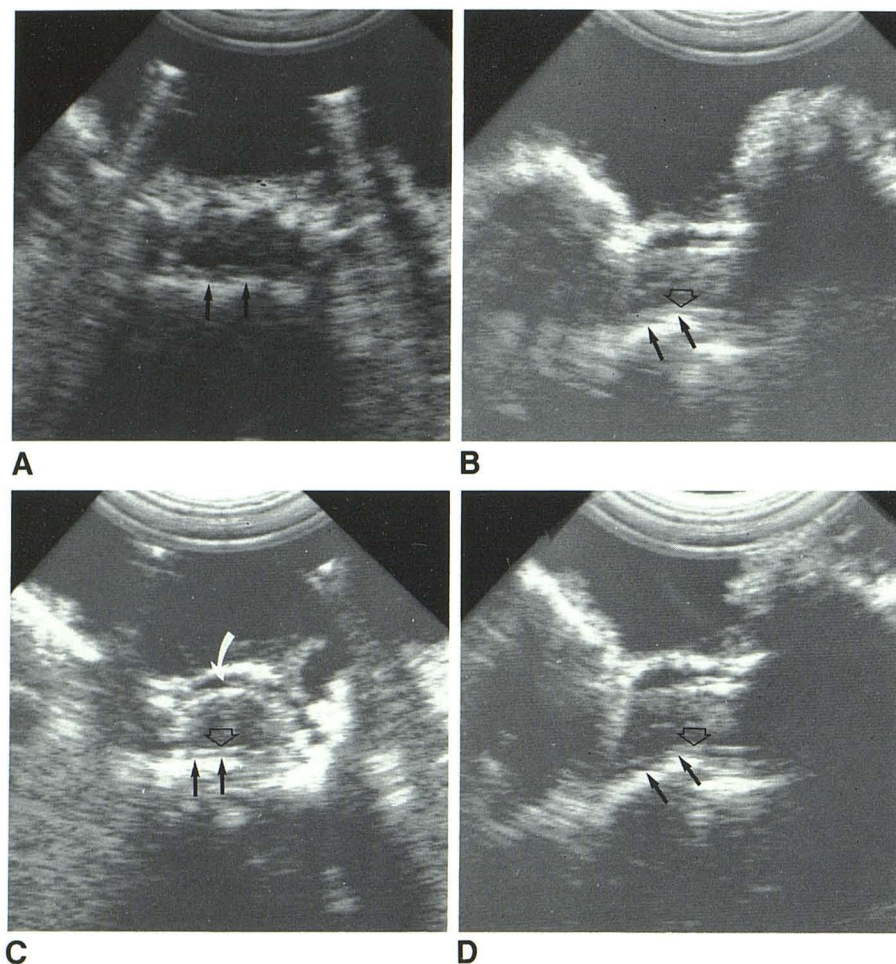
Inadequate decompression after HRI; increased Harrington rod distraction performed, but canal still not adequately decompressed; nothing further done because patient neurologically intact. Initial transverse (A) and longitudinal (B) intraoperative sonograms obtained after HRI for T12 fracture. Compression of distal spinal cord by displaced bone fragment (arrows). In B, bone can be seen reaching and distorting ventral surface of spinal cord (open arrow). Because of these findings, Harrington rods were distracted further, which resulted in only slight improvement in vertebral malalignment. Transverse (C) and longitudinal (D) sonograms. Some CSF (curved arrow) now seen dorsally, but distortion of ventral cord surface (open arrows) by displaced bone fragments (straight arrows) persists. Because patient was neurologically intact, it was decided not to attempt to further decompress canal, despite this demonstration of vertebral malalignment.
